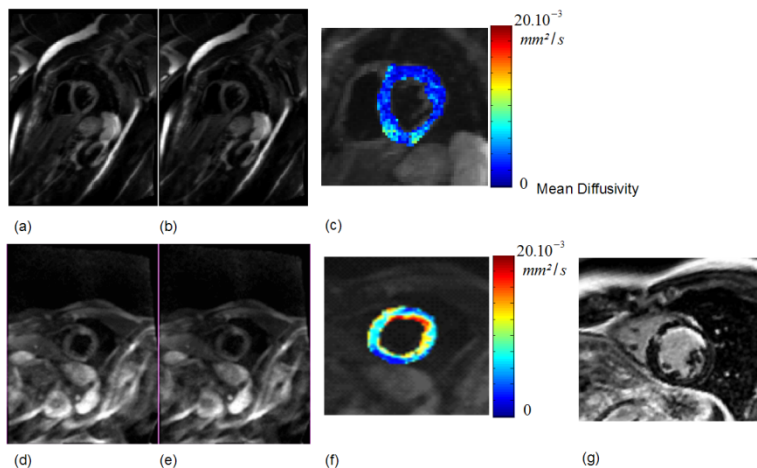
PCA-tMIP DWI results on a healthy volunteer(a-c) and a patient with anterior non transmural scar(d-g)
